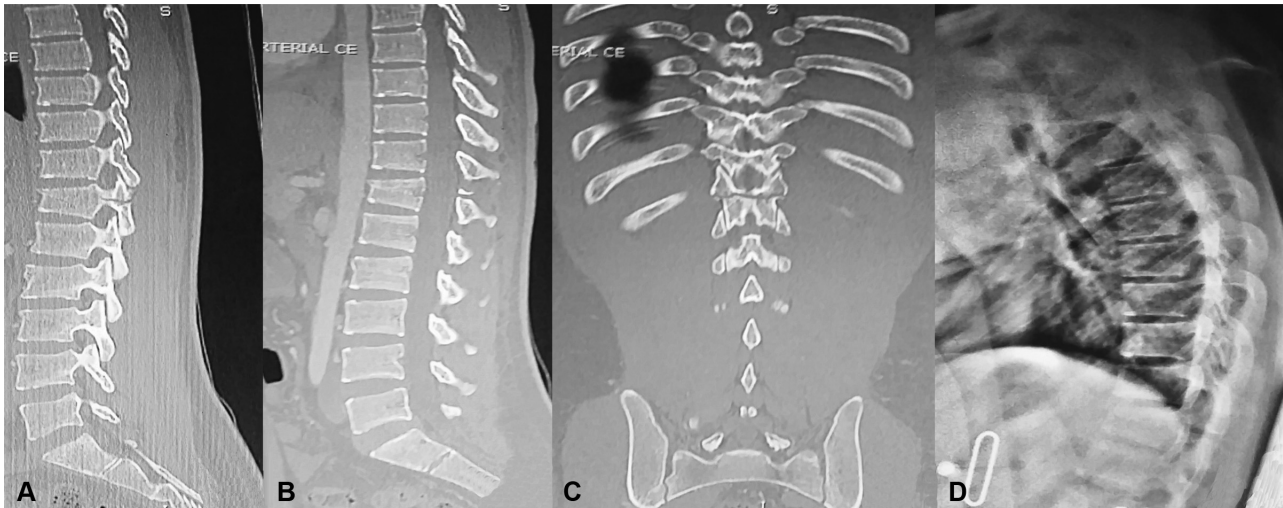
Sagittal computed tomography scan of a T12 subtype B1 (Chance) fracture showing pedicle fracture (A) and some vertebral body compression (B) at T12. Coronal CT scan showing a compression fracture from pedicle to pedicle passing through the lamina of T12. The patient was walking with mild pain and no neurological deficits, asking for a trial of non-operative management. Standing lateral thoracic plain radiograph with a brace (D).
